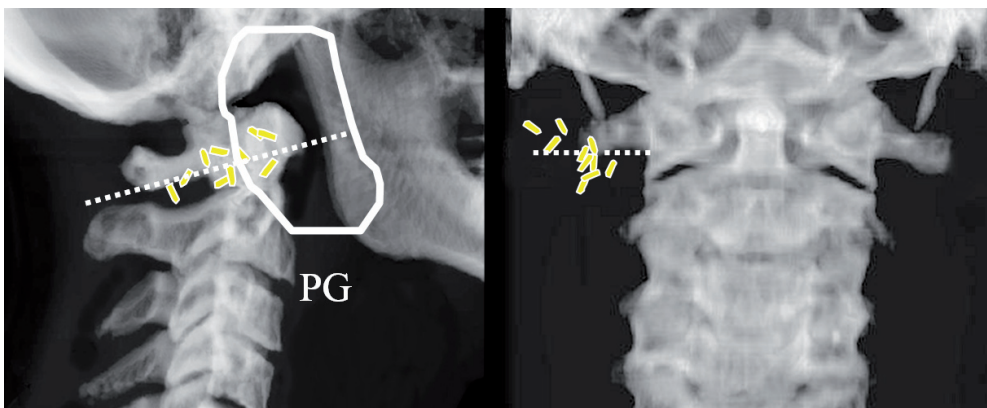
Projection of clips (AP and Lateral X-ray films) placed intra-operatively at cranial border node negative neck. Clips cluster around caudal border transverse process corpus vertebra C-I. See also projection of circumference of parotid gland (PG) as determined by CT.
